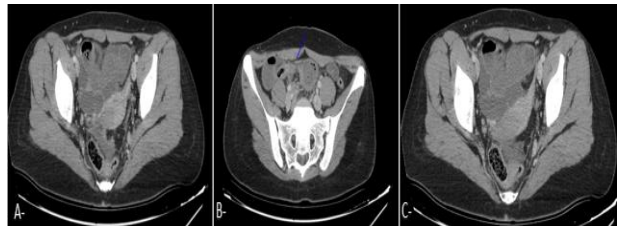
CT scan showing (A) the uterus, left fallopian tube, and left ovary appeared normal, with no anomalies detected. The right fallopian tube was not visualized; (B) the organic small bowel obstruction identified upstream of a whirlpool sign (blue arrow) in the hypogastric region, indicative of a small bowel volvulus; (C) visible right ovary, absence of visualization of the right fallopian tube.
